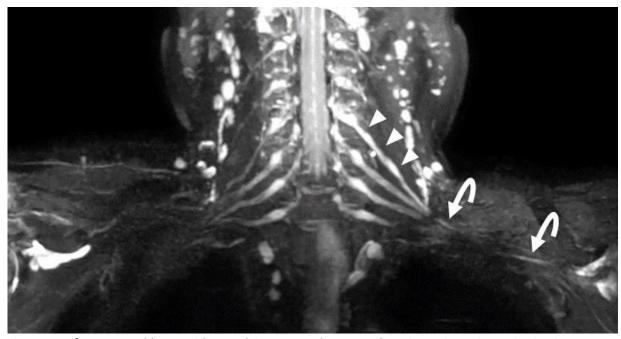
MRI of a 65-year-old man with neuralgic amyotrophy. Coronal maximum intensity projection image. Left C5 nerve root show asymmetrical hyperintensity with undulating pattern (arrowhead) and left upper trunk has higher T2 signal intensity compared with the right (curved arrow).
